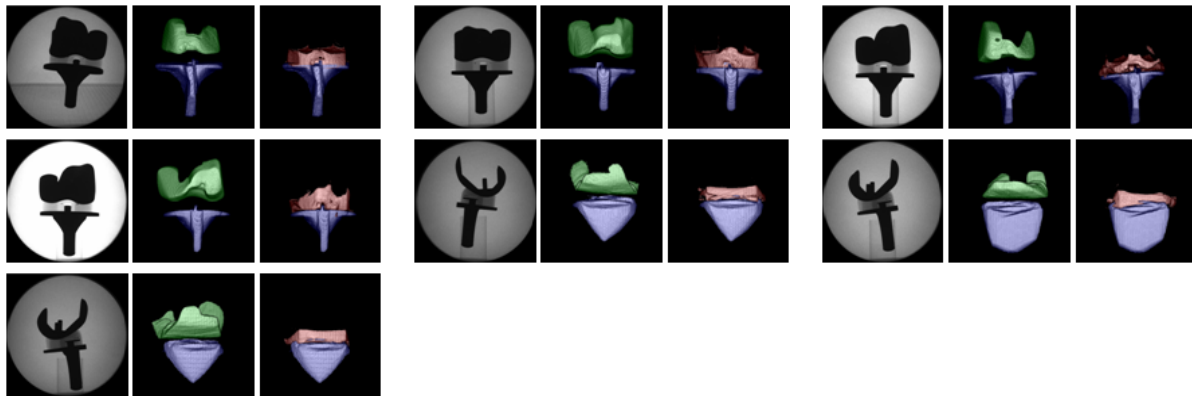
3-D reconstructed TKA implant with FVH. Left: Raw X-ray image. Center: Femoral and tibial components. Right: Tibial insert and component. Top left to bottom right: #1 to #7.
